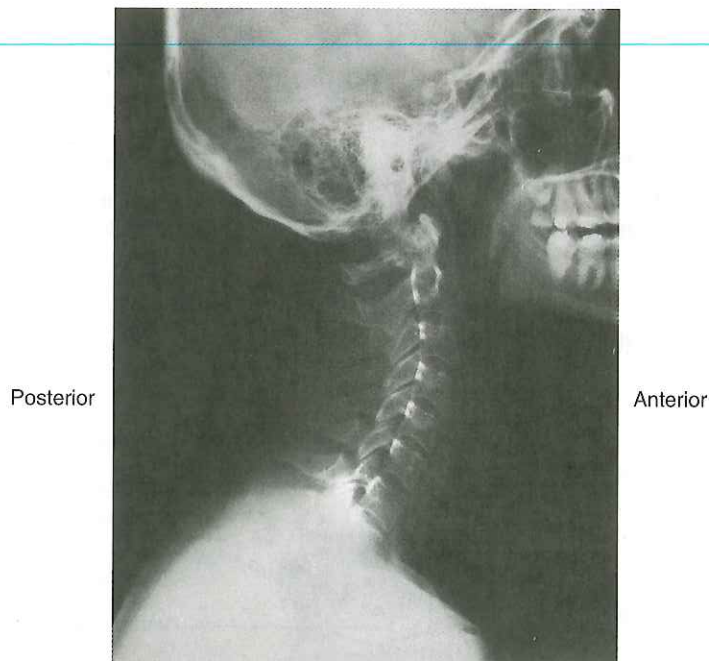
Radiograph of the cervical vertebrae.
